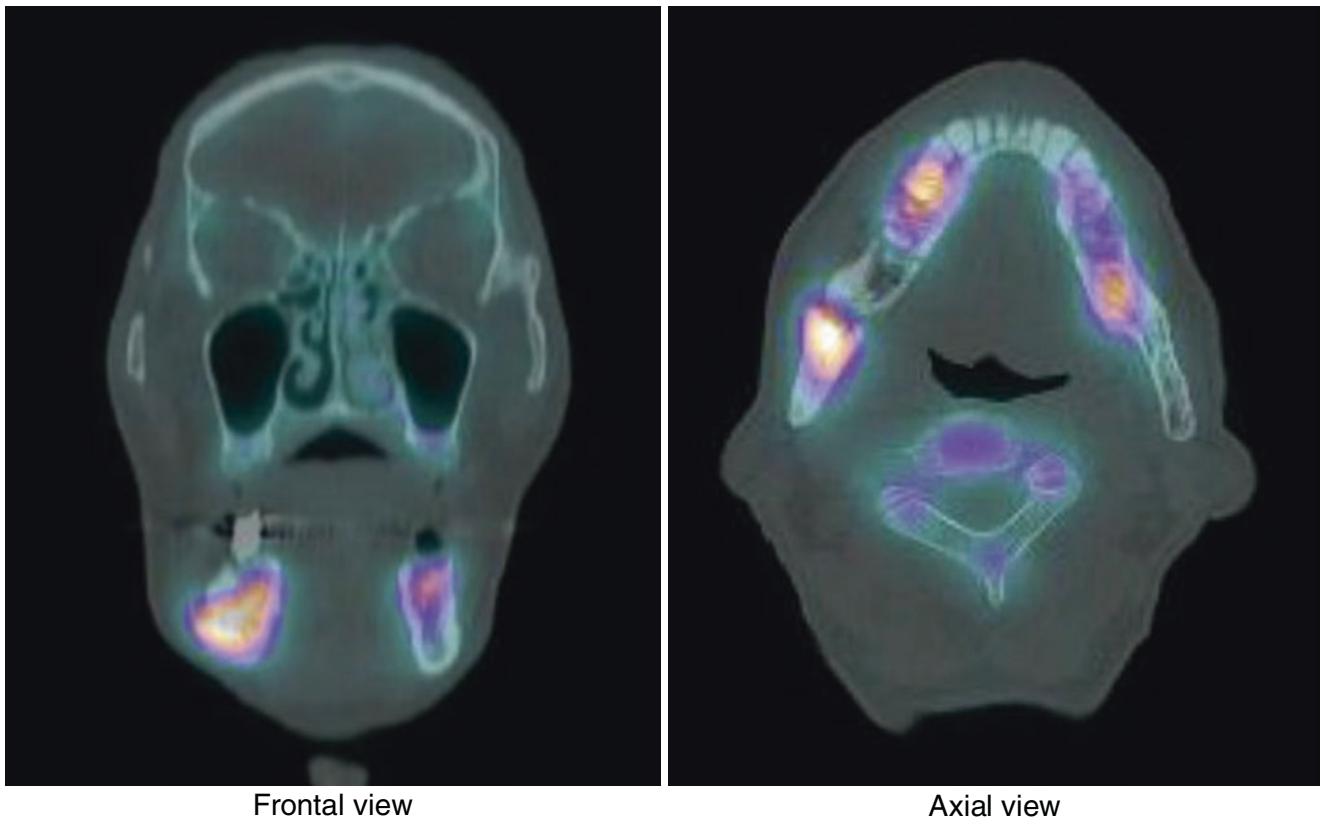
SPECT/CT. Frontal view (left) and axial view (right)
